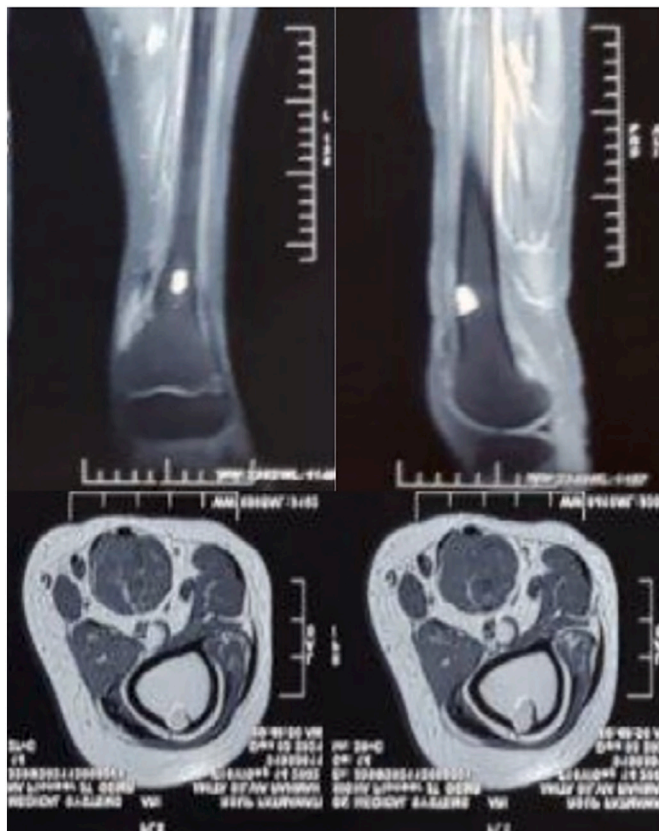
T2 weighted MRI images of the distal femur showed hyperintense signal on both coronal and sagittal view. T1 weighted MRI images axial view showed isointense lesion with hypointense margin.
